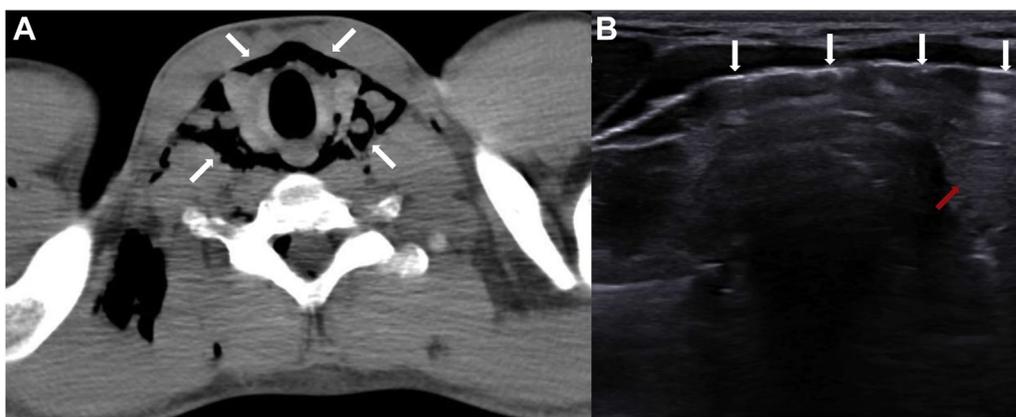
The air is visible in the surrounding thyroid parenchyma on the axial view both of cervical CT imaging (white arrows) (A) and cervical ultrasound (B). In the latter, the acoustic barrier prevents the visualization of the underlying tissues (white arrows), with the exception of a portion of the left thyroid lobe (red arrow).
